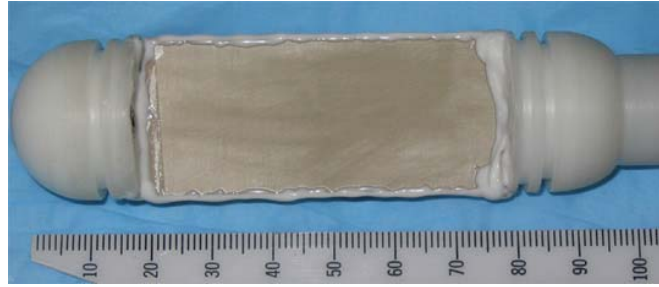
A photograph showing the transrectal probe utilizing prototype array #2, after assembling the soldered array and the appropriate brass tubes into the MRI compatible housing.
